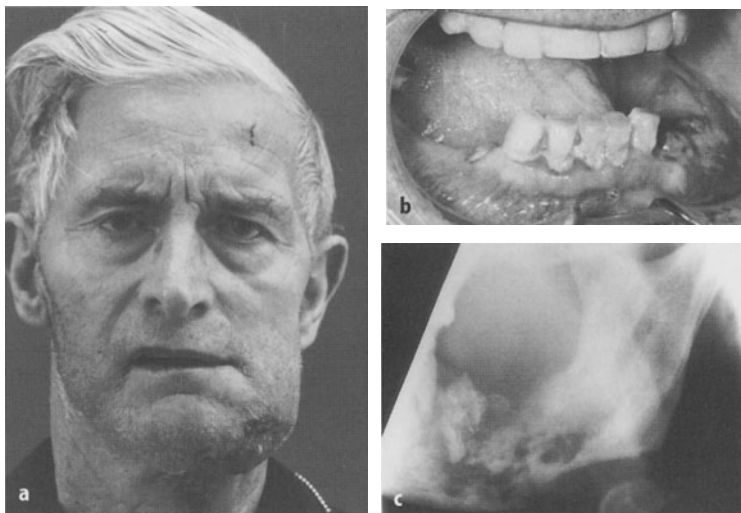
Enlargement of a rib graft used for immediate reconstruction of a horizontal ramus destroyed by osteomyelitis. a, b Patient's preoperative outward appearance and oral situation with several fistulae discharging pus. c Lateral oblique radiograph of the affected side of the mandible showing the extent of osteomyelitic destruction of the mandible and a large sequestrum better than the panoramic view
